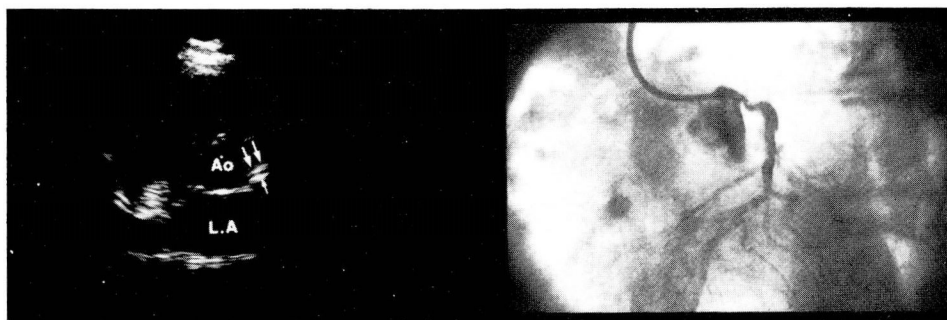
Short axis left parasternal view at the level of the aorta in a patient with an ostial lesion in the left main trunk. Notice that the walls of the vessel have increased reflectivity and the lumen is narrowed at the origin.
